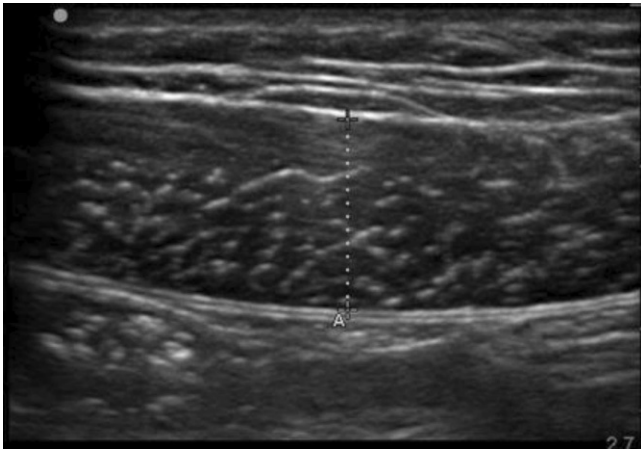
▲ RA Ultrasound image. RA Rectus Abdominis
